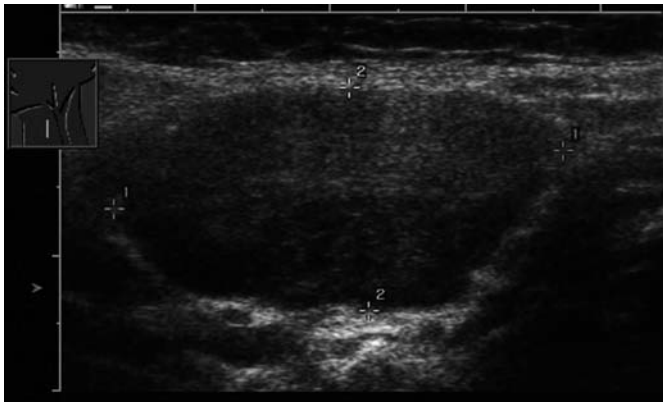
A typical lymph node conglomerate of an aggressive lymphoma with several lymph nodes of low echogenicity. The sonographic examination shows the facet formation with lymph nodes abutting each other.
